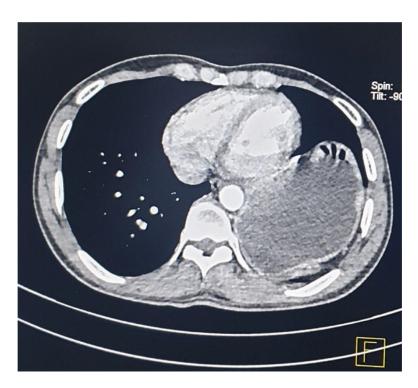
Contrast-enhanced axial CT image showing the herniated stomach lying in the left posterior aspect of the thoracic cavity.
